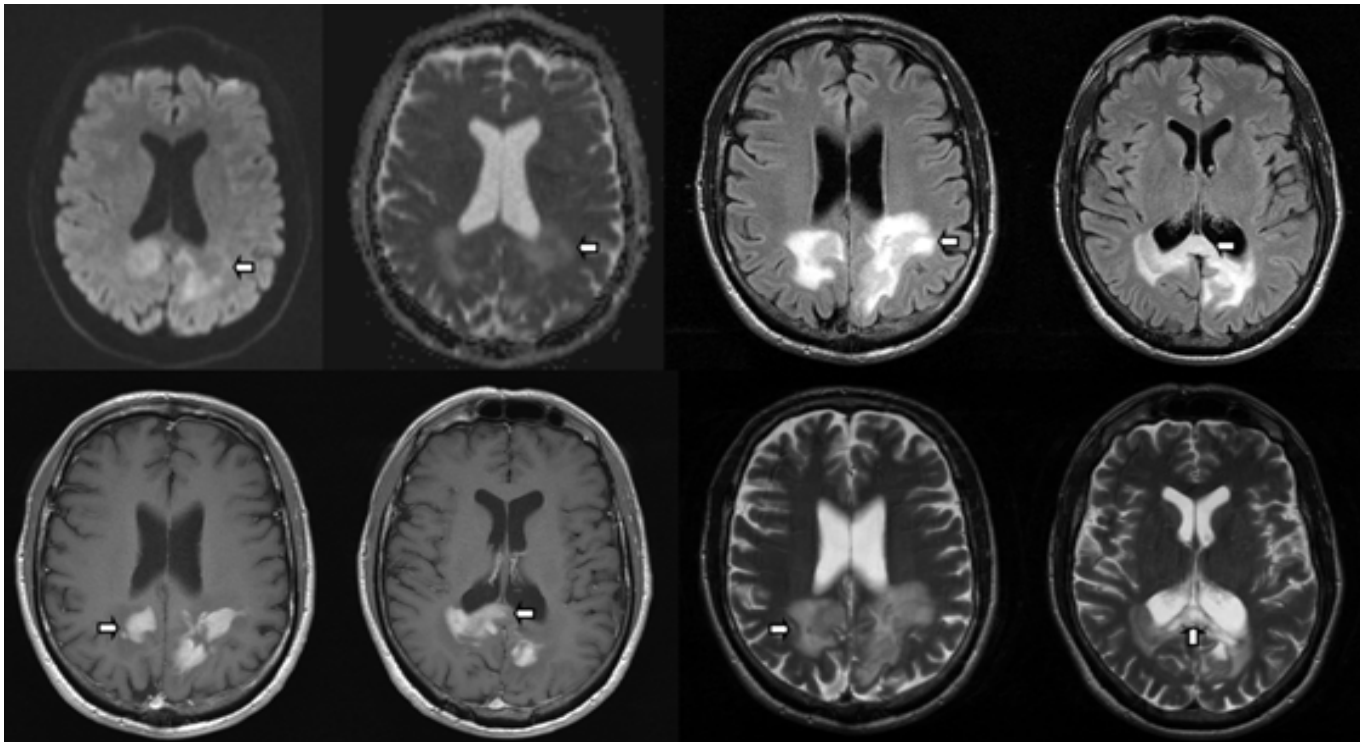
Brain MRI with provided DWI/ADC sequences (top left) demonstrate mild restricted water diffusion associated with a mass in the bilateral parietal lobes and splenium (arrows). FLAIR sequence (top right) demonstrate perilesional vasogenic edema within the splenium of the corpus callosum and in the adjacent parietal lobes (arrows). T1 weighted post contrast sequence following administration of IV gadolinium (bottom left) demonstrate discontinuous, homogeneous enhancement (arrows). T2 sequence (bottom right) demonstrates an isointense mass in the splenium of the corpus callosum and in the adjacent parietal lobes with surrounding vasogenic edema (arrows).
